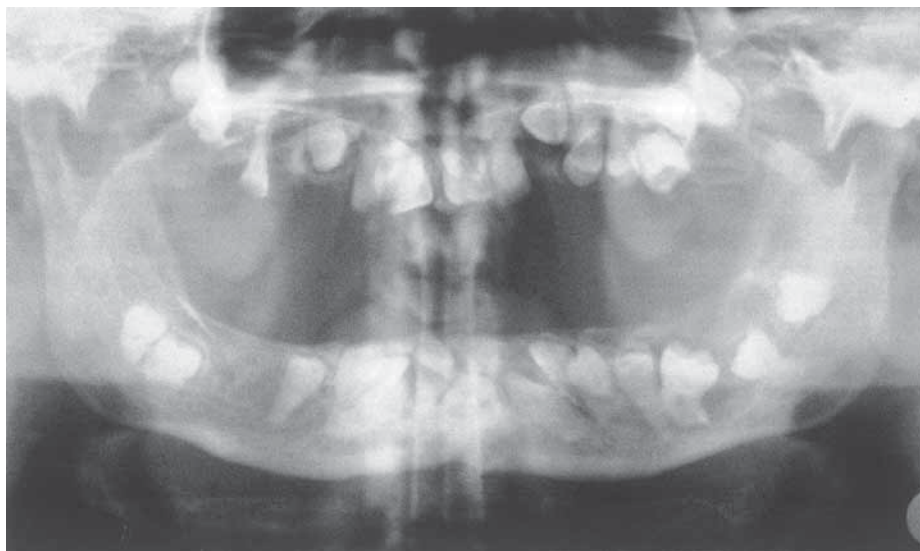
Orthopantomogram showing unerupted teeth.
